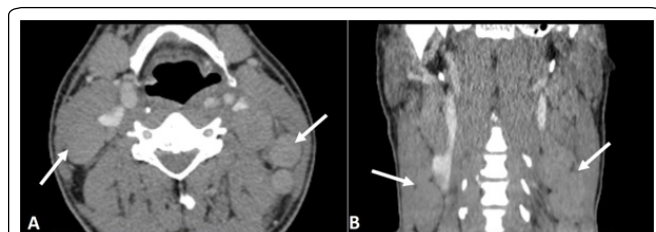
Neck CT acquisition after iodinate contrast administration at the axial plane (A) and reconstruction at the coronal plane (B), depicting several bilateral cervical lymphadenopathies (arrows).
